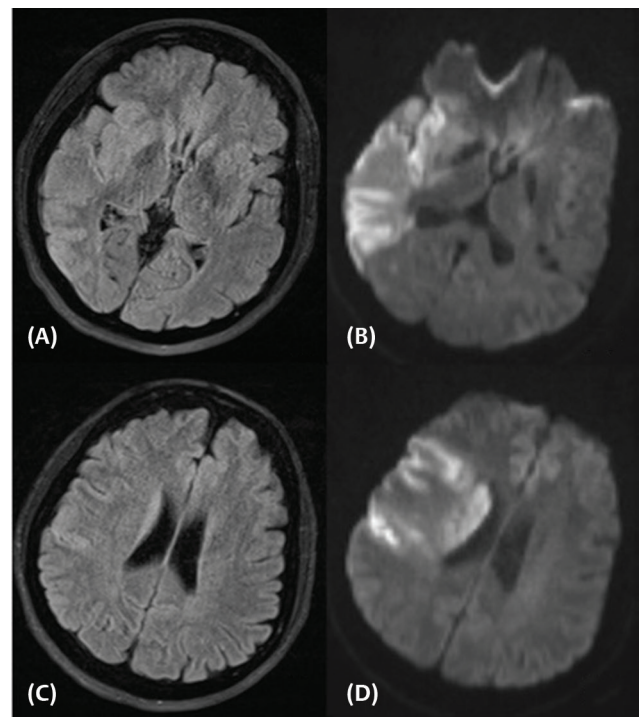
Axial fluid-attenuated inversion recovery (FLAIR) weighted (A, C) and diffusion weighted (DW) (B, D) magnetic resonance imaging (MRI) images showing mismatch in the FLAIR and DW hyperintensities suggesting that the ischemic insult is within 3 to 4 hours and the patient can potentially benefit from reperfusion therapy. (FLAIR signal changes are not clearly seen while the diffusion changes are well appreciated.)
